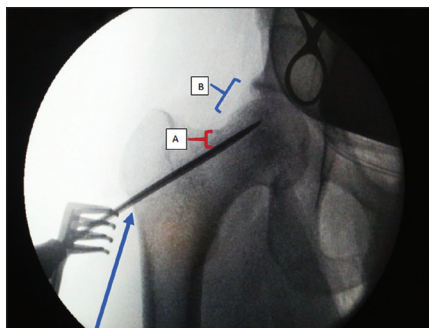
Surgical process details. The arrow indicates the high entry point of the guidewire at the vastus ridge targeting the area of osteonecrosis. A, 1-cm distance from the superior cortex to prevent fracture. B, varus appearance of the proximal femur due to mild flattening of the femoral head in the anterolateral femur in early osteonecrosis of the femoral head. This is the earliest sign observed radiographically and is indicative of stage IIB.
